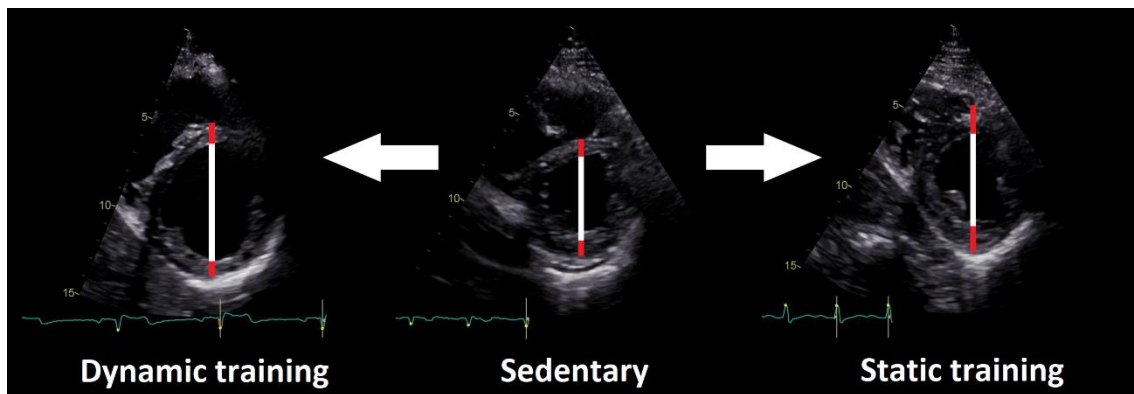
The Morganroth hypothesis in clinical practice. Dynamic (isotonic) training is associated with significant excentric hypertrophy, as seen on the left echocardiogram of a professional swimmer. Static (isometric) training results in concentric hypertrophy of the left ventricle, demonstrated by the echocardiogram of a powerlifter athlete on the right (parasternal short-axis views). White lines: end-diastolic diameter, Red lines: septal and posterior wall thickness
